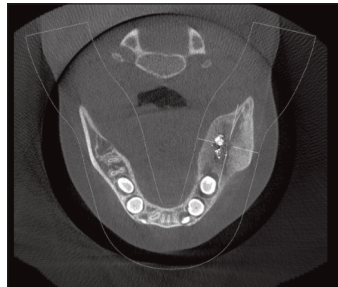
Post operative Axial section of CBCT.
